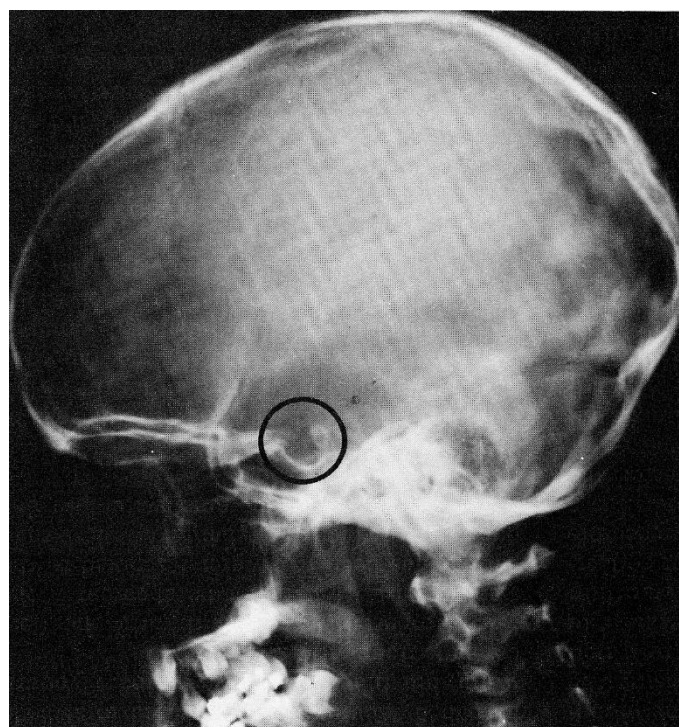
The sella turcica is well seen on this lateral view of a plain skull radiograph.
